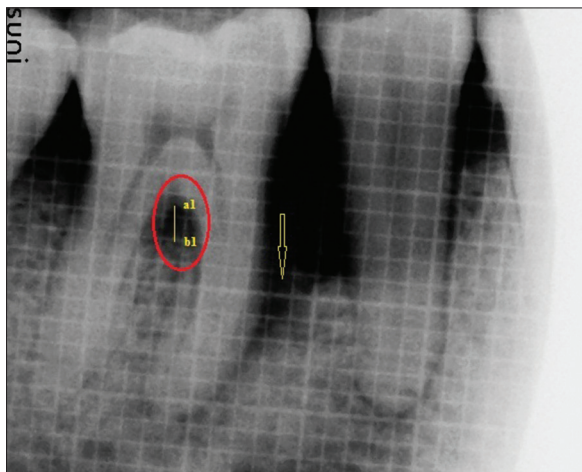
4 months postoperative radiograph showing reduction furcation defect having ~ 1.5 mm vertical dimension (a1 and b1) (Also, arrow showing defect fill mesial to the right mandibular molar)
